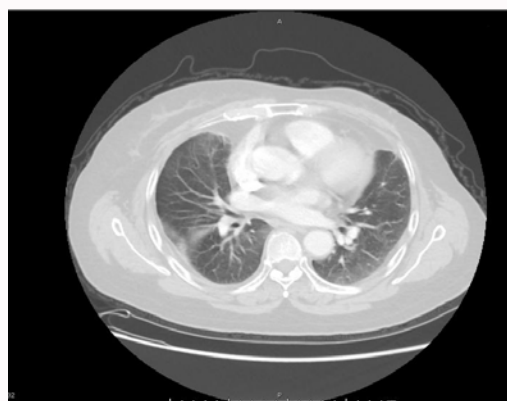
Case 2: Interstitial infiltrates in the pulmonary lower left lobe found on routine CT scan in asymptomatic patient.
